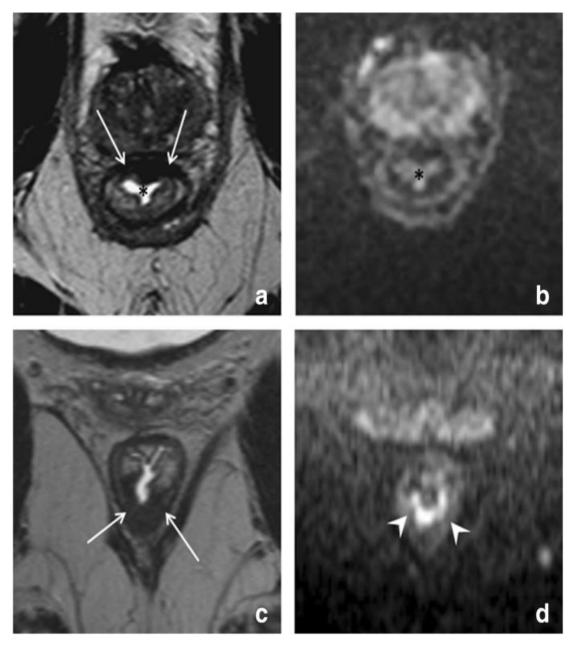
MR images showing the importance of DWI imaging in assessment of rumor reponse.[9]
